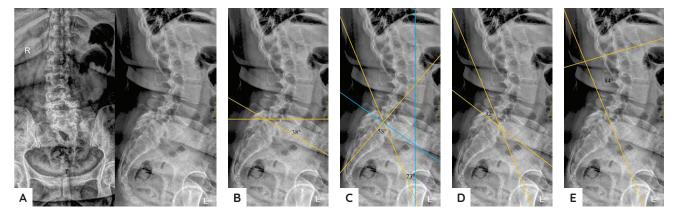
Showing lumbosacral AP-Lateral X-ray pre-operatively: anterior-posterior-lateral (A); sacral slope (B); pelvic incidence and pelvic tilt (C); slip angle (D); lumbar lordosis angle (E).
